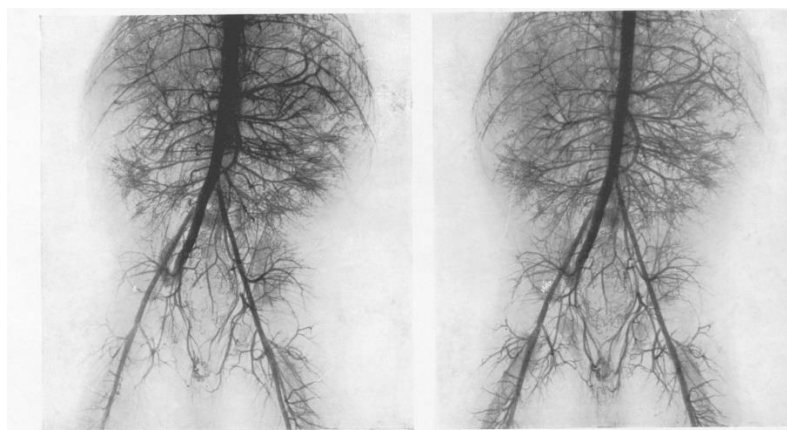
Stereoscopic radiographs of the abdominal vessels. The plate was designed to be cut out of the book and viewed in a hand-held stereoscope. From Orrin (1920).
